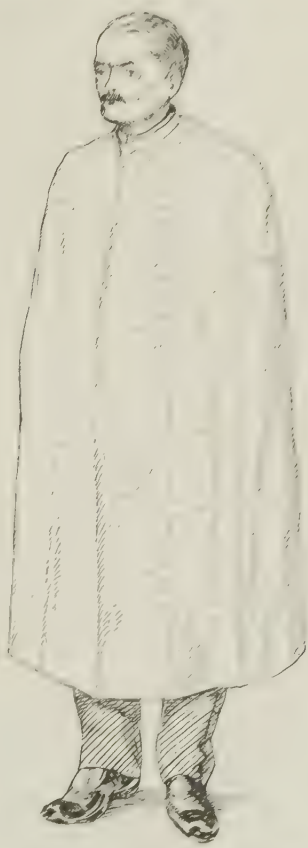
SPECTATOR'S GOWN OF UNBLEACHED MUSLIN.
